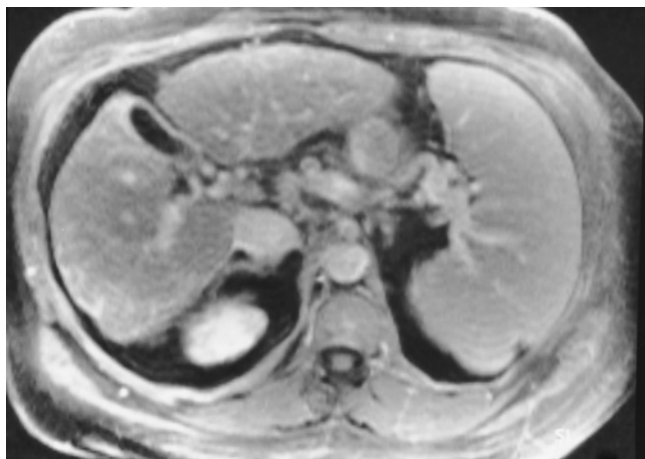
Porcelain gallbladder. Diffuse calcification of the gallbladder wall was seen on a CT examination (not shown). The T1-weighted 2-min postgadolinium fat-suppressed GE image demonstrates uniform enhancement of a smooth 3-mm-thick gallbladder wall, which excludes superimposed malignancy.
